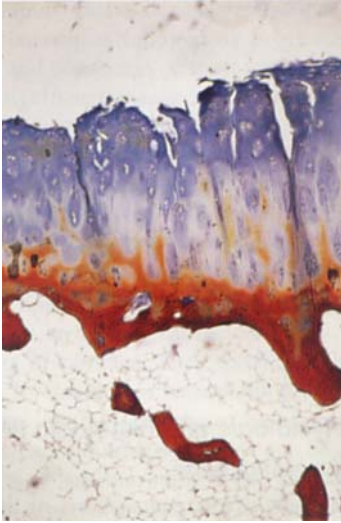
Cartilage and osteochondral end-plate from a patient with intraosseous engorgement-pain syndrome of the hip (radiographically silent arthrosis; MSB, x40).
